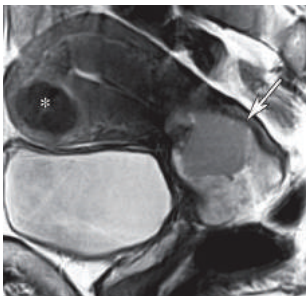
Sagittal T2-weighted image showing a cervical mass (arrow) of mixed hyperintensity that involves all of the cervical canal and extends into the lower uterus, but does not involve the outer stromal layer, vagina or adjacent organs. A fibroid (*) is incidentally noted.
